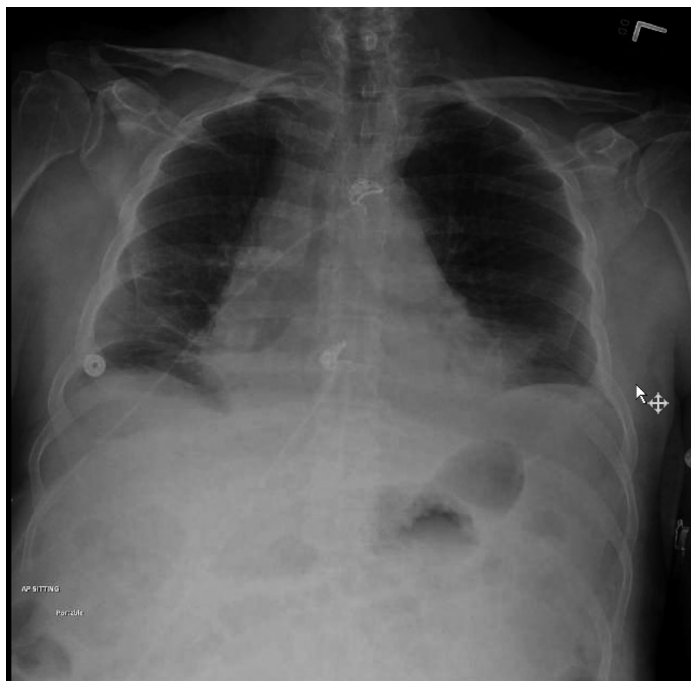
Portable chest X-ray displaying a globular heart suggestive of pericardial effusion
